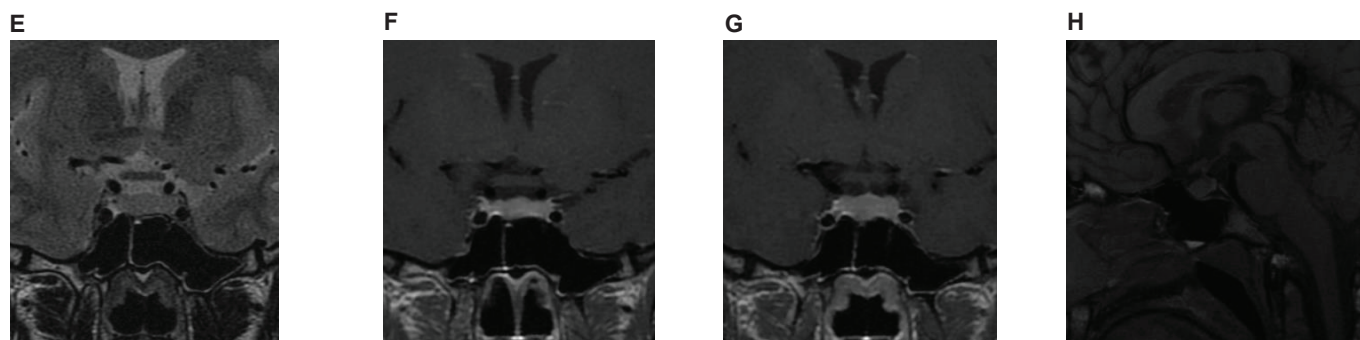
Follow-up MRI of the pituitary gland after 12 months of levothyroxine treatment showing the complete resolution of the pituitary enlargement. Coronal (E, F and G) and sagittal (H).
